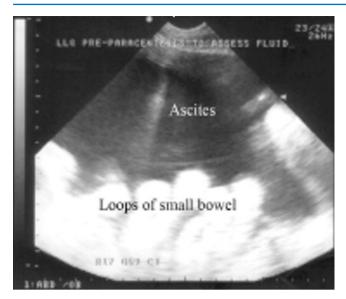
Ultrasound to determine whether there is a pocket of fluid that can be drained
